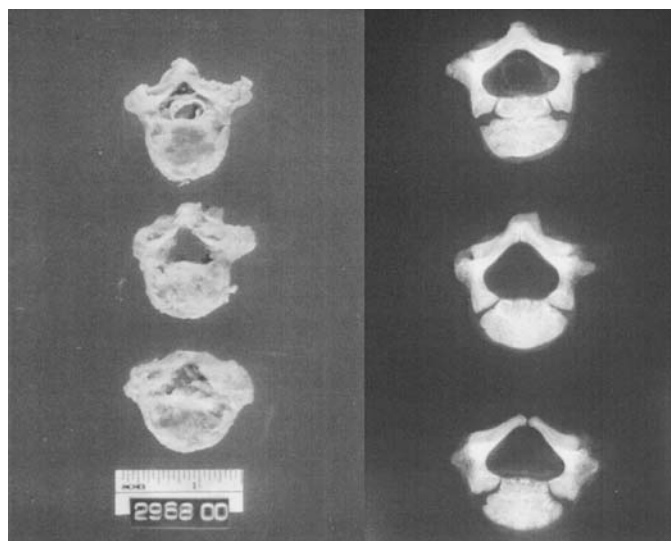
Gross examination of L3 through L5 with corresponding X-rays revealing a complete coronal cleft of the centrum of L3 and slight indentations of the lateral aspects of the centrum of L5.
